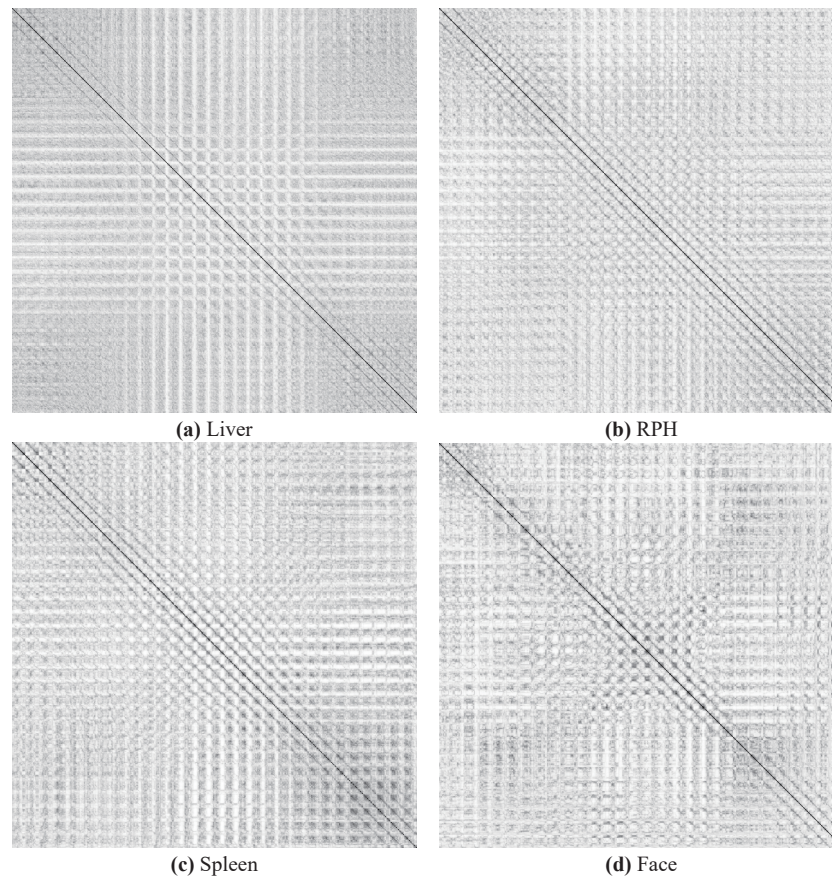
Average FRPs of extravasation in sequential CT.
